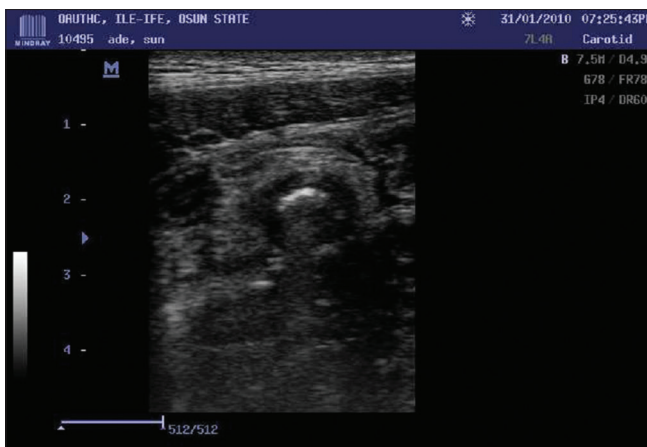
Transverse sonogram of an inflamed appendix with appendicolith showing a characteristic target sign
